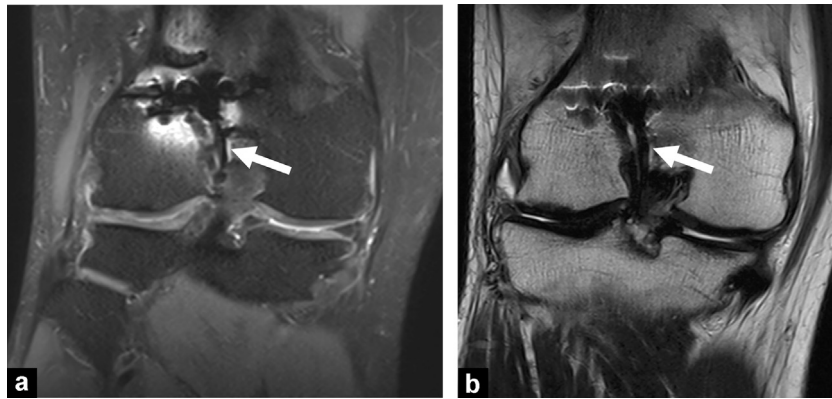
A better morphologic definition of the reconstruction is obtained on non fat-suppressed sequences. Coronal fat-suppressed-PD- (a) and T2-weighted MR images (b).
